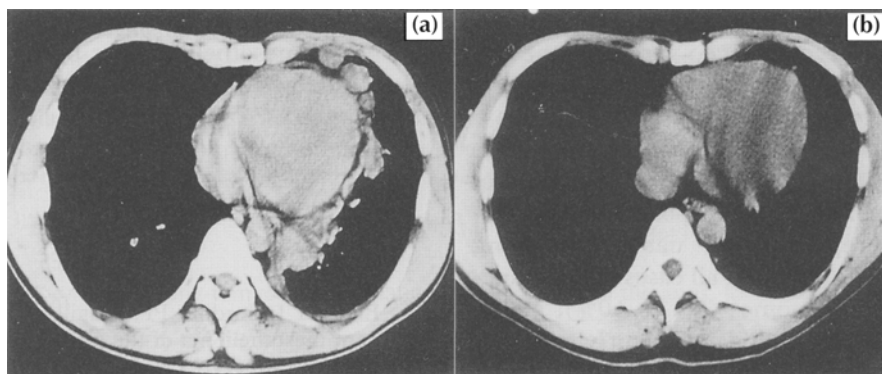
(a) Contrast-enhanced, chest computed tomography scan in the patient described in Fig. 1, and also taken at the time of referral, shows multiple nodular lesions in contact with the pleura of the left lung. (b) Contrast-enhanced computed tomography scan of the chest in the same patient obtained the following March 10 shows an almost complete regression of the pleural lesions.
